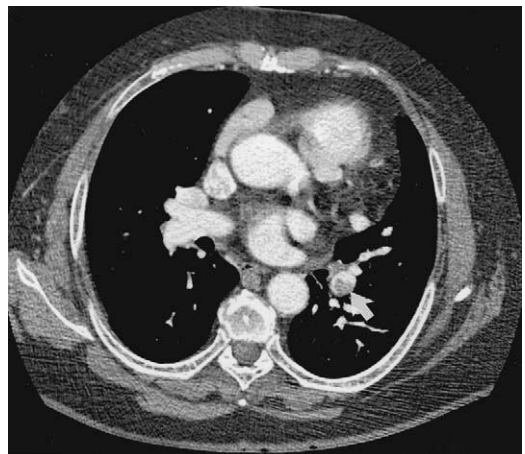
Acute PE. Multidetector spiral CT image shows a partial filling defect in left lower lobe pulmonary artery (arrow), outlined by contrast and forming an acute angle with the vessel wall.
